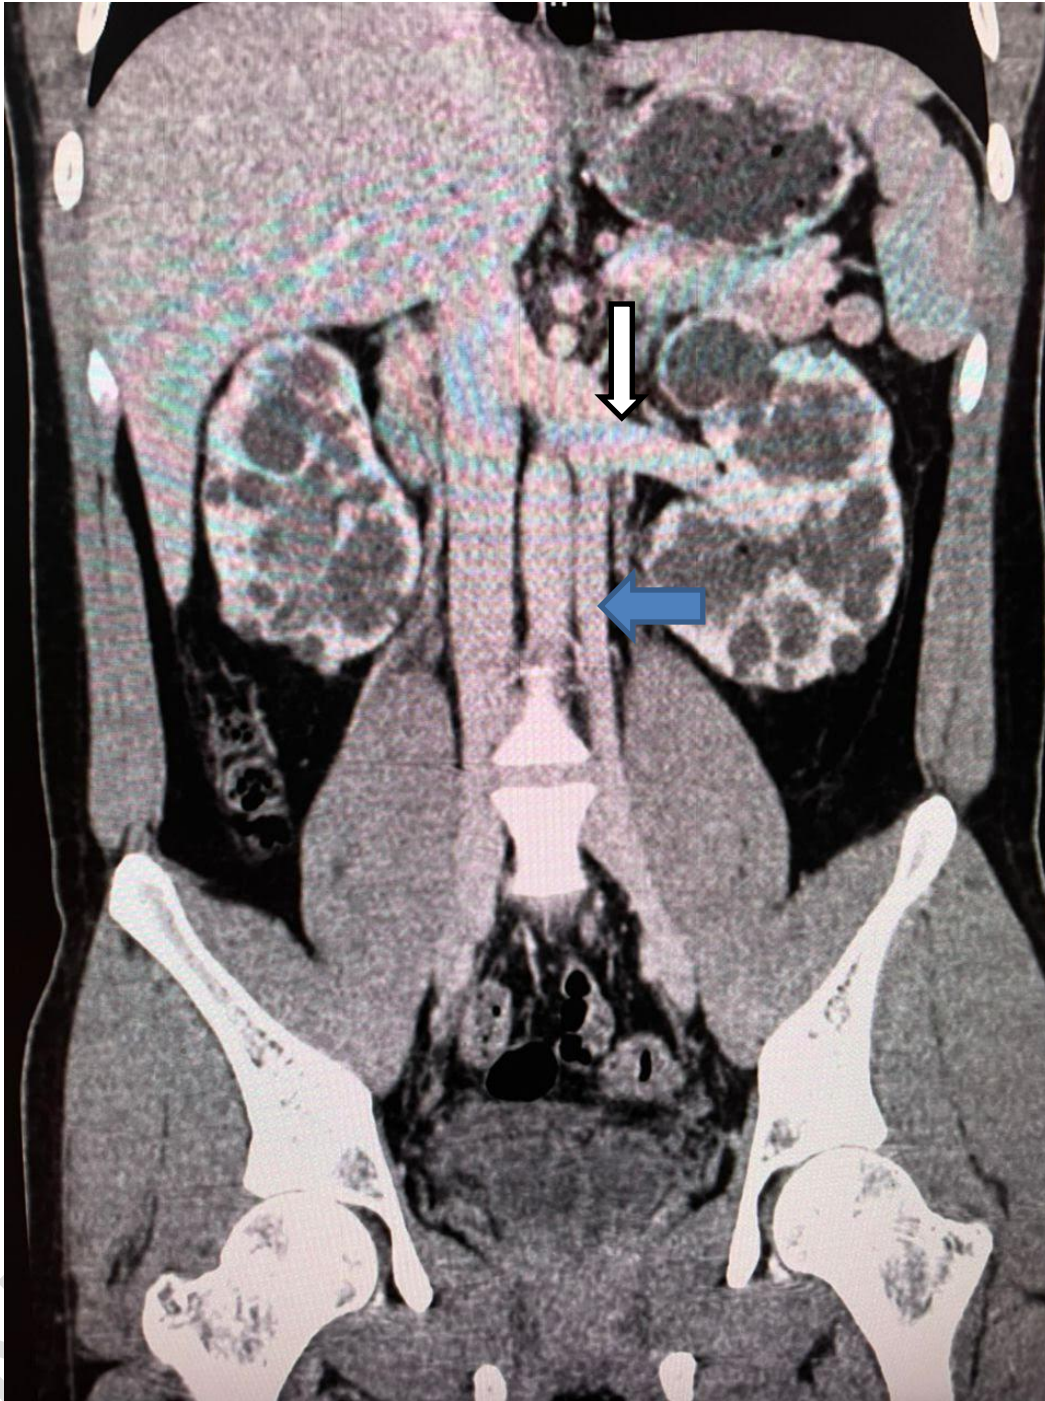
CT scan demonstrating left-sided vena cava (blue arrow) draining into the left renal vein (white arrow). The right-sided IVC can also be visualized separately from the left-sided vena cava.
